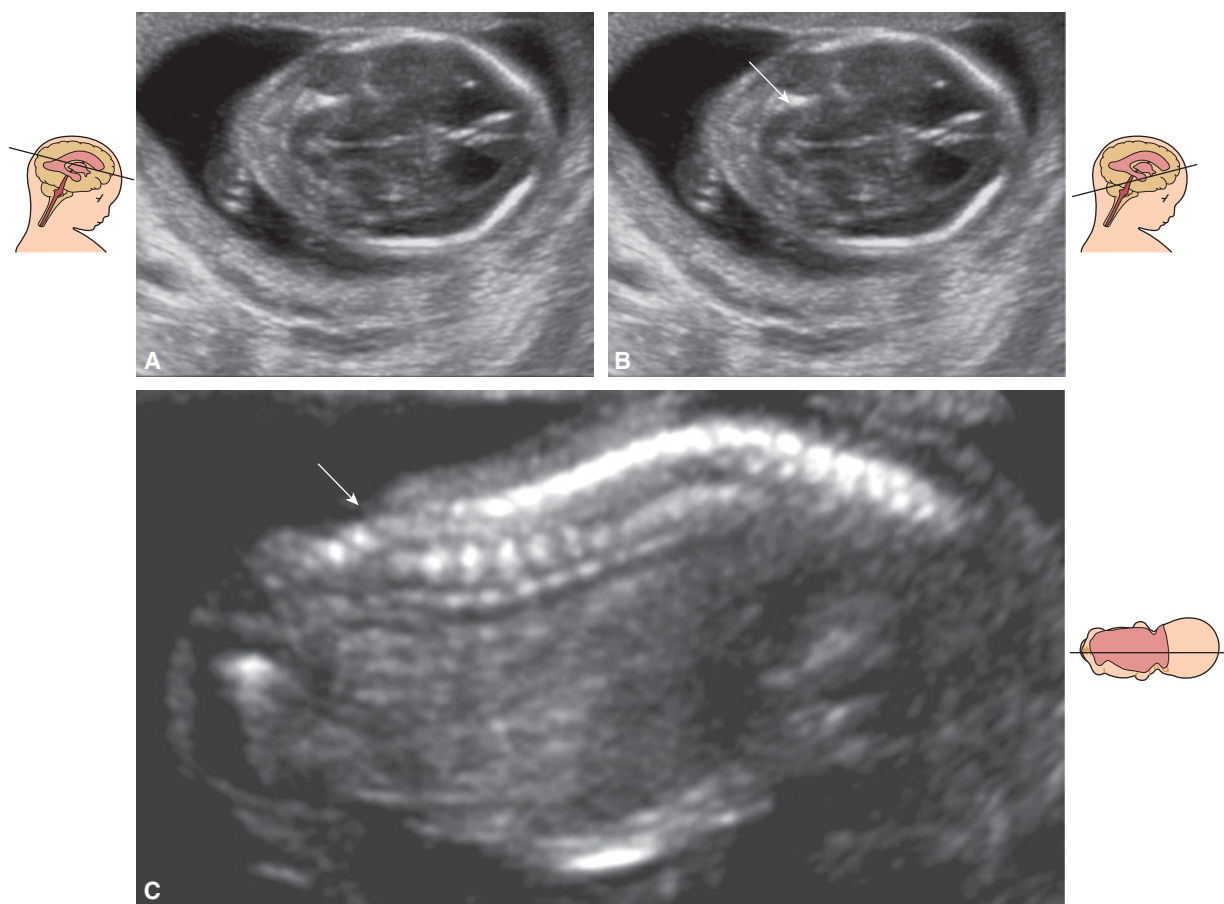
A transabdominal scan in a patient at 18 weeks, 3 days with elevated maternal serum alpha-fetoprotein showing the most common sonographic findings in cases of Chiari II malformation. (A) The fetal head clearly shows the “lemon” sign, which is a deformity of the frontal bones. (B) In the posterior fossa, the cerebellum (*arrow*) shows the “banana” sign, which is the result of an inferior displacement of the cerebellum and vermis obliterating the cisterna magna. (C) Sagittal view of the spine showing the large spinal defect (*arrow*).
